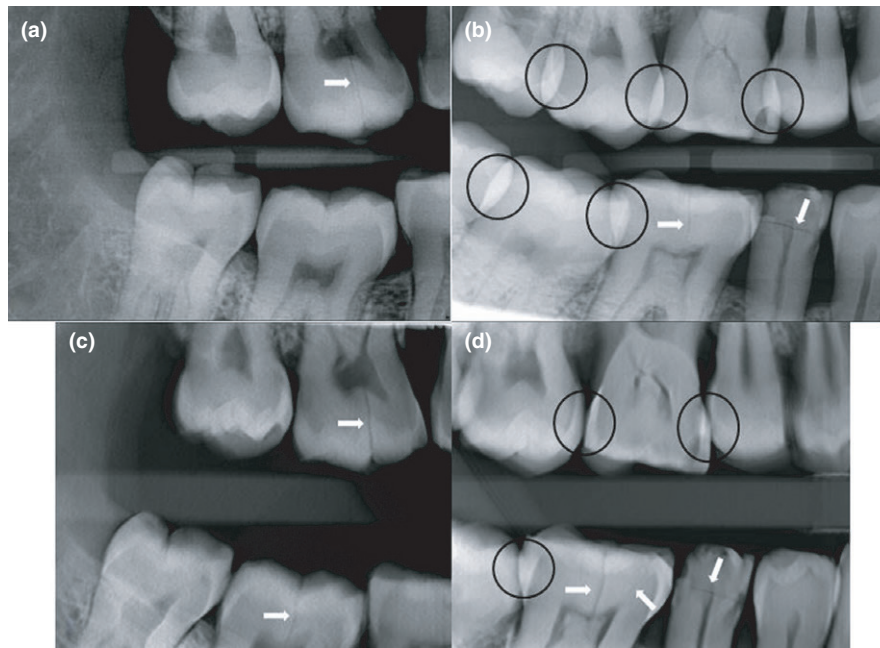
2D images (top) and reconstruction slice images (bottom) from DXTR bitewing acquisition. Reconstruction slices reveal more fractures (arrows), with higher contrast. Interproximal superposition (circled) in the 2D premolar image (b) is eliminated in the corresponding reconstruction slice (d).
